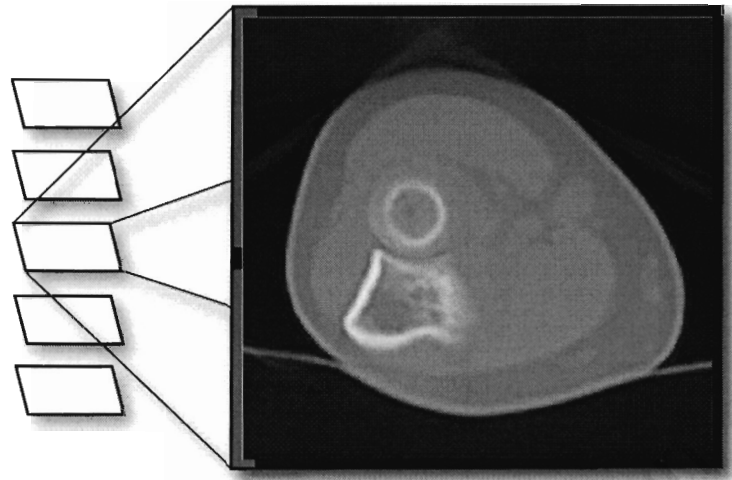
CT Slice: An example of an CT image from the stack of image slices that make up a CT scan of the lower forearm. Notice that there are distinct intensities that signify different densities. It is this contrast between densities that radiologists find so helpful in CT scans.
